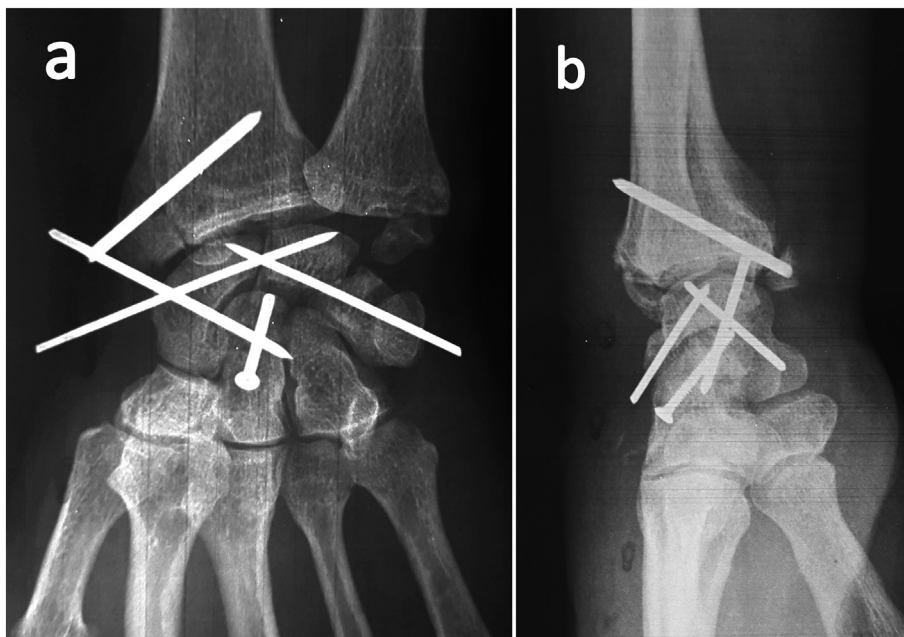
Posteroanterior (a) and lateral (b) radiographs of the right wrist after surgery.
